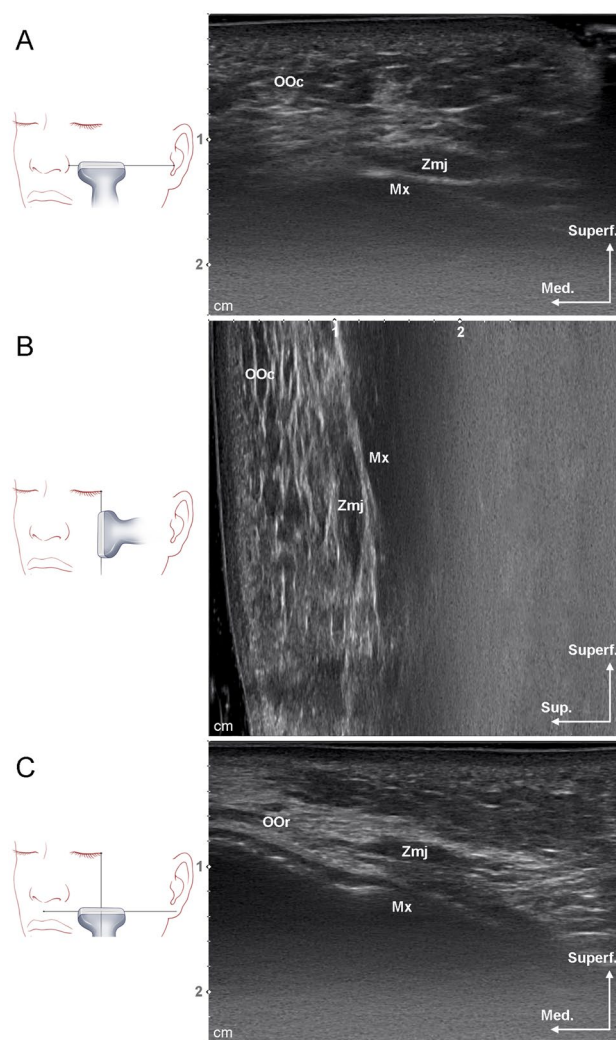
Ultrasound images of the Zmj. At the horizontal level of the nasal ala, the fibers of the Zmj arising at its origin observed in transverse A and longitudinal B views. C Zmj fibers in the transverse view were found on the maxilla (Mx) where H2 crossed P. Superf, superficial; Med, medial
